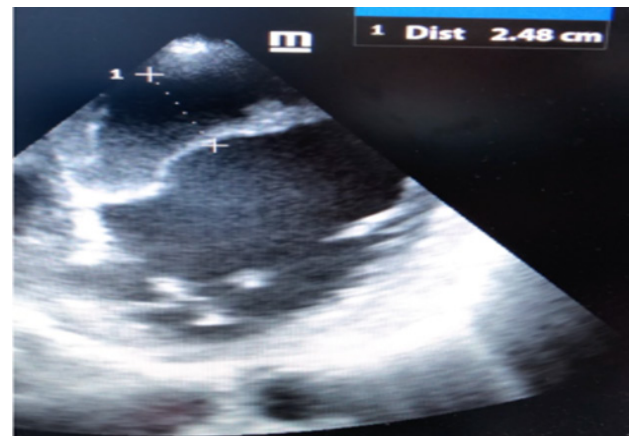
Echocardiography image showing the size of the dissected cavity between the outer layer (myocardium and pericardium) & inner layer (thin myocardium and endocardium)
